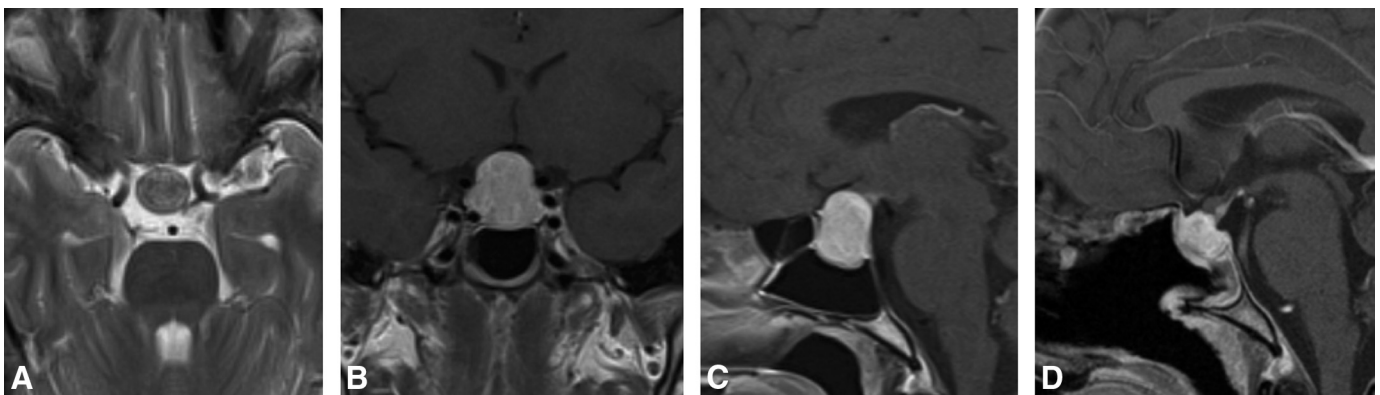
Lymphocytic hypophysitis. Axial T2WI (A) and coronal (B) and sagittal (C and D) postgadolinium T1WI of a patient with lymphocytic hypophysitis. A 31-year-old postpartum woman with headache, fatigue, and vision loss. Axial T2 (A), coronal T1 (B), and sagittal T1 postcontrast (C) images demonstrate a large sellar-suprasellar mass, with superior displacement of the optic chiasm—features that mimic a pituitary macroadenoma. During surgery, the appearance of the gland was inflammatory and a biopsy was obtained, which demonstrated attenuated infiltrate of the B and T lymphocytes, consistent with the diagnosis of lymphocytic hypophysitis. Sagittal T1 postgadolinium image (D) obtained as part of follow-up MR imaging 3 weeks after starting steroid treatment demonstrates an interval decrease in size of the sellar-suprasellar mass, as well as postsurgical changes related to the trans-sphenoidal approach.
